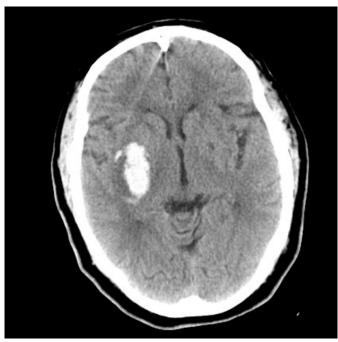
Head CT image with intracerebral hemorrhage (right lenticulocapsular nucleus).
